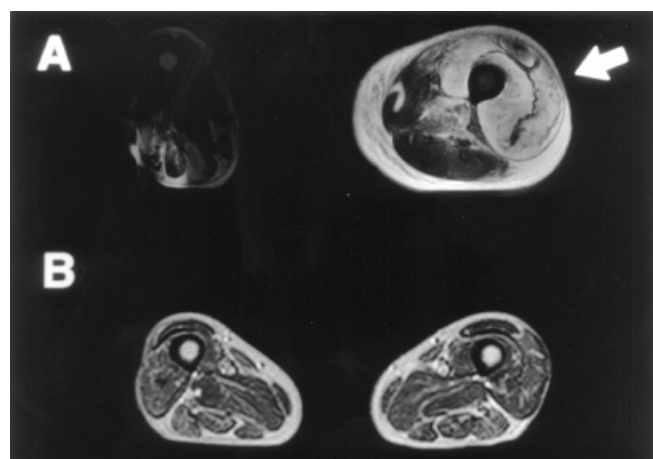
(A) Axial T2-weighted (TR 4500/TE 99) MR image of the left mid-thigh on admission demonstrated an abnormal high-signal area in the vastus lateralis muscle, the vastus medialis, the rectus femoris muscle, the vastus intermedius, and the sartorius muscle (arrow). (B) Axial T2-weighted (TR 3000/TE 104) MR image of the left mid-thigh on day 50 showed disappearance of the abnormal signal
